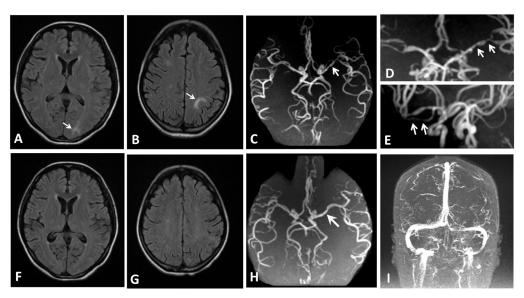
On the ninth day after admission, following a second episode of headache triggered by coughing, cerebral MRI revealed recent infarcts with symmetric hyperintense lesions in the left occipital lobe on T1-weighted images (A and B). MRA showed multiple alternating segments of constriction and dilation of cerebral arteries (C, D, and E). Follow-up MRI, MRA and MRV performed on the 45th day after discharge demonstrated resolution of the previous abnormalities and normalization of segmental vasoconstriction (F, G, H and I).
